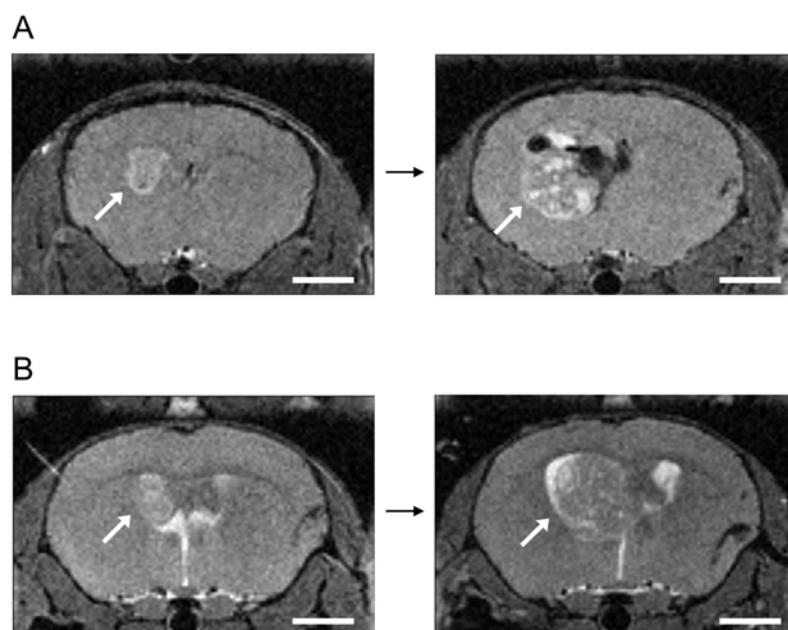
Growth of BT474-Gluc metastatic brain tumors when established by IC and IV injection of breast cancer cells, as monitored by MRI. (A) IC-formed brain tumors. (B) IV-formed brain tumors. Scale bar, 2 mm.
